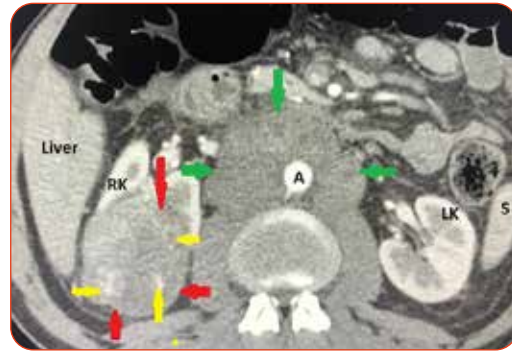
Enhanced axial CT scan showing tumour mass arising from the upper and middle poles of the right kidney (red arrows) in keeping with renal cell carcinoma (RCC). Yellow arrows show calcifications. There is para-aortic lymphadenopathy (green arrows) in keeping with metastatic spread. A = aorta. LK = left kidney. S = spleen.
